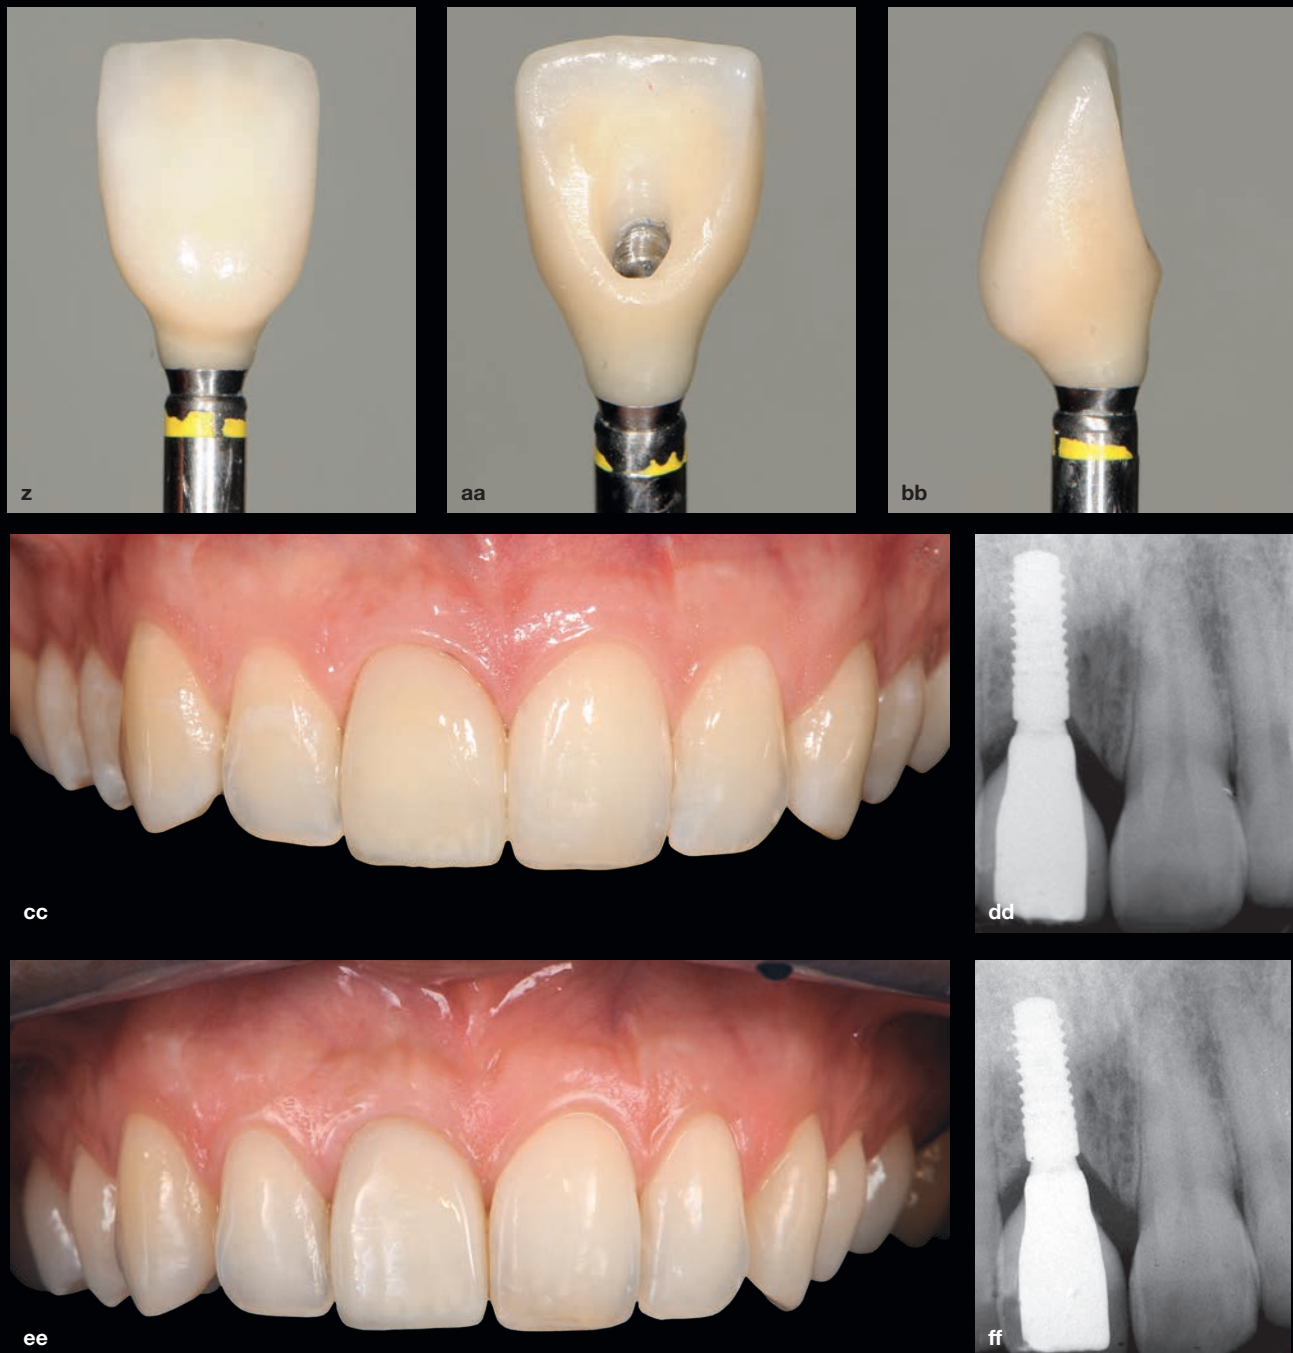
(cont) (z to bb) Note also the gradual emergence profile from the implant-prosthetic connection to the supragingival portion of the restoration by means of platform switching. With thin soft tissues, forming a harmonious emergence profile without steps and excessive tissue compression is considered an important factor for long-term stability of the soft tissue profile. (cc) Appearance of the implant-supported crown after delivery. The restoration appears to be well integrated into the surrounding soft tissues. The incisal margins form a convex line that is more pleasing than the original straight line, and the symmetric shape of the central incisors is favorable. (dd) A radiograph shows the marginal bone levels. (Surgery and prosthetic rehabilitation by Dr P. Casentini; laboratory stages by Mr A. Schoenenberger.) (ee to ff) The 5-year follow-up images show favorable medium-term prognosis of this implant-supported prosthetic rehabilitation and the stability of hard and soft tissues. →
